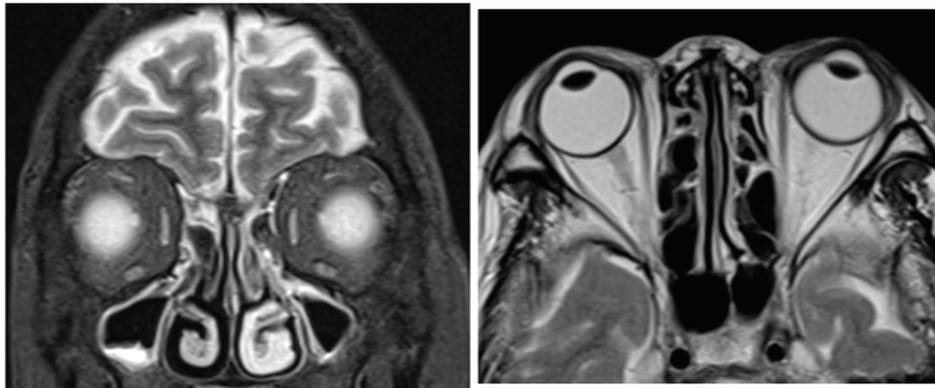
Preoperative MRI examination showed diffuse extra ocular muscle atrophy on coronal view (a) and axial view (b).
